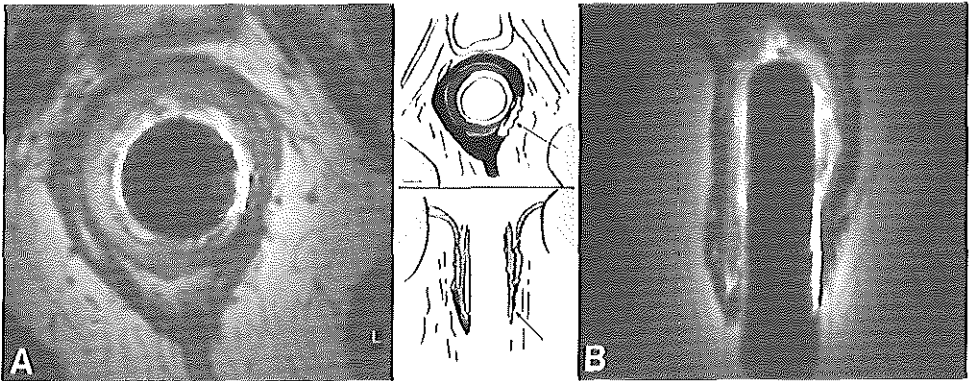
Localized scarring.* Axial (A) and coronal MRI (B) in a male (31) with faecal incontinence after fistulectomy. On the right, normal muscle layers are present. On the left, there is a localized scarring (arrow) of all layers.
